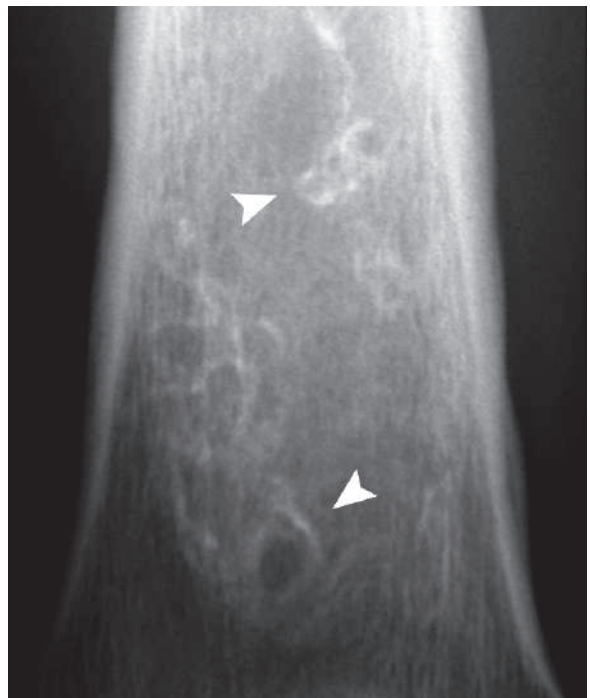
Plain radiograph of the distal femur metaphysis shows radiolucent areas surrounded by sclerotic rims (arrowheads) due to old bone infarction in a patient with sickle cell disease (SCD)
